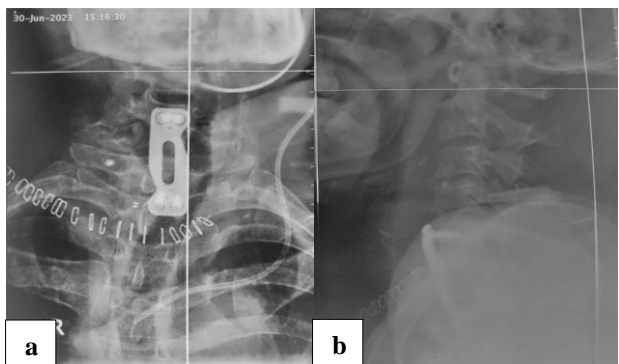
(a and b): Postop-X-ray.
